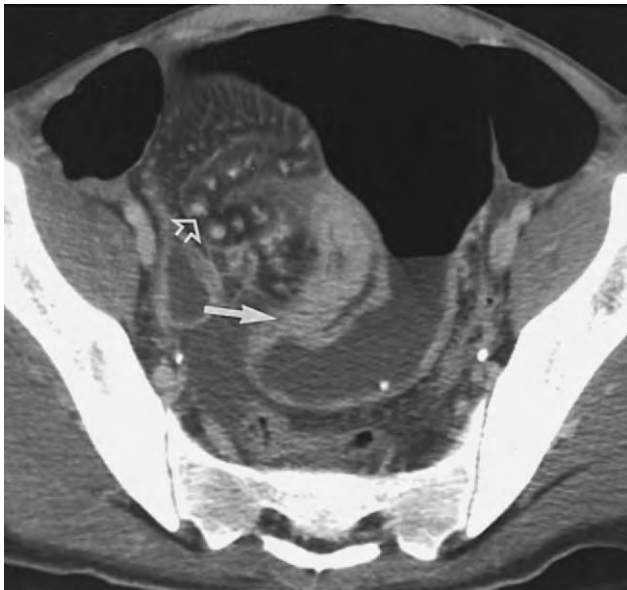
High-grade obstruction as a result of Crohn's disease. Computed tomography demonstrates a grossly dilated, gas-filled small bowel proximal to a narrowed, thick-walled, enhancing segment of Crohn's disease (*solid arrow*) that was causing obstruction. Dilated vessels are seen in the mesentery (*open arrow*). (From Herlinger H, Caroline DF: Crohn's disease of the small bowel. In Gore RM, Levine MS [eds]: *Textbook of Gastrointestinal Radiology*, vol 1, 2nd ed. Philadelphia, WB Saunders, 2000, p 737.)
